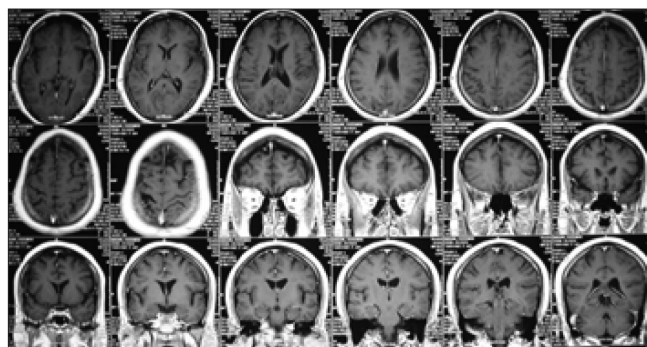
Brain MRI with contrast two months later & without active leison
